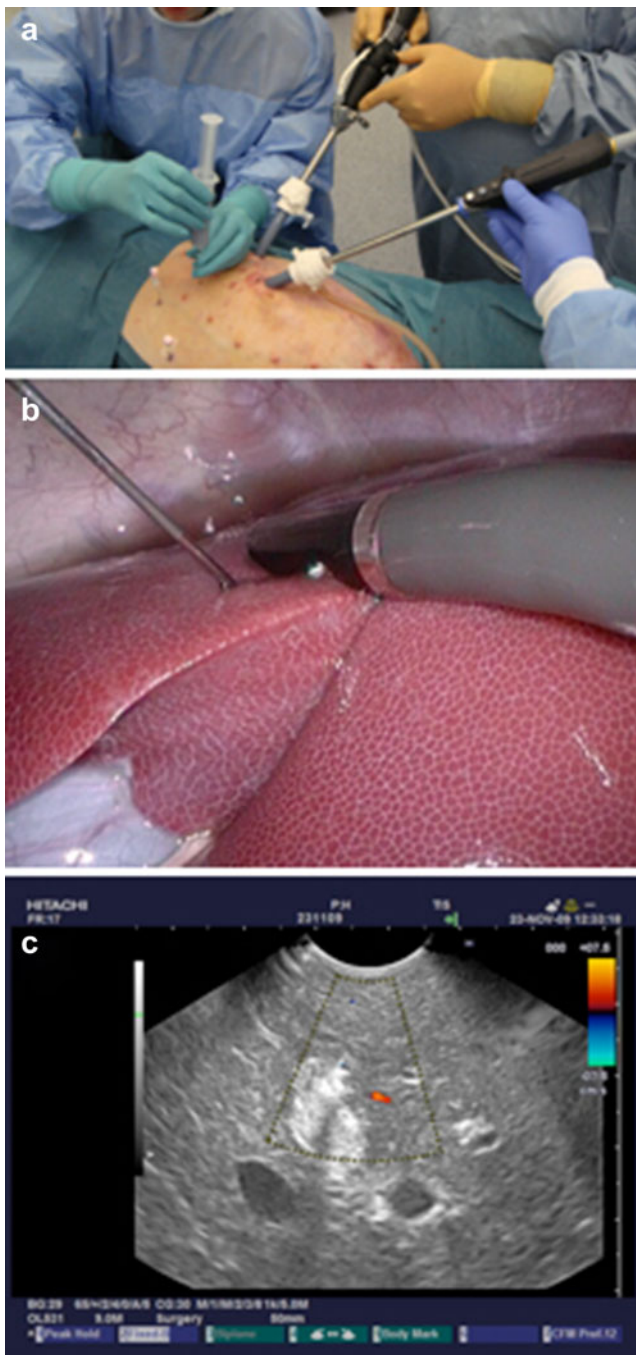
Laparoscopic ultrasound (LUS)-guided injection of the liver model tumors. a Overview showing two needles used to inject tumors and one in progress. Laparoscope and LUS probe are used for guidance. b Laparoscope video image showing the LUS probe tip and one needle. c LUS image of hyperechoic tumor with color flow imaging. The needle is causing the shadow in the image (in part of the tumor). Color flow is used to avoid blood vessels.
